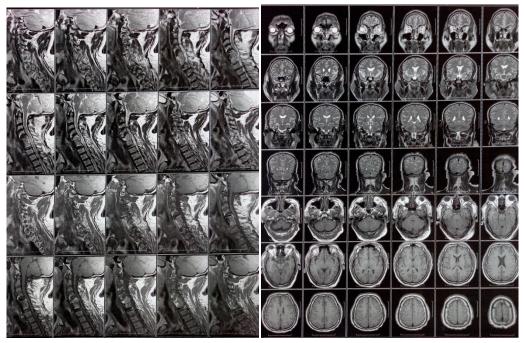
[A] MRI of the cervical spine and [B] MRI of the Brain
